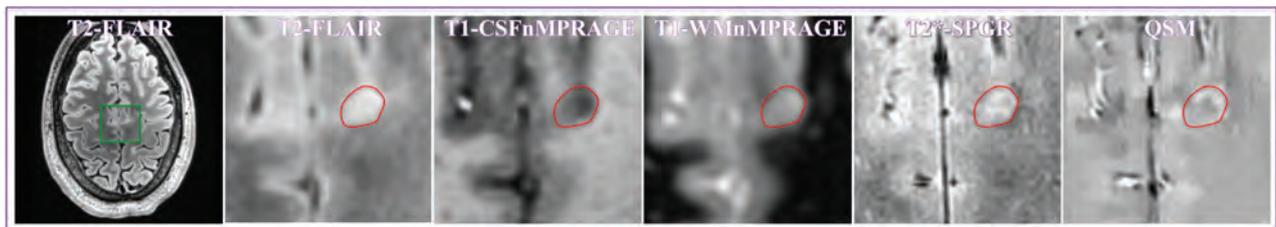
MR images of the only cortical lesion from patient 2. The lesion had a positive relative susceptibility and demonstrated a hyperintense core surrounded by an asymmetric hyperintense rim, suggesting that the lesion may have iron at its edge. Please see the Fig 3 legend for image descriptions.
